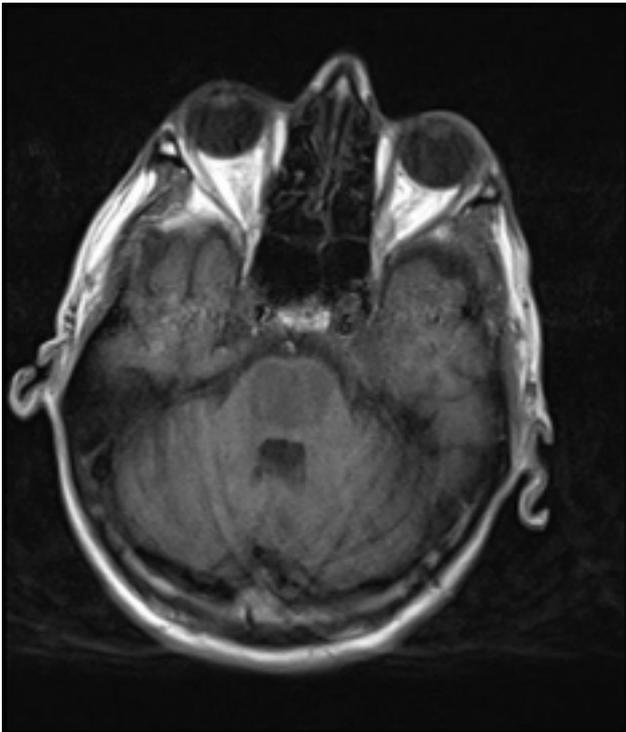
MR imaging of central pontine myelinolysis
